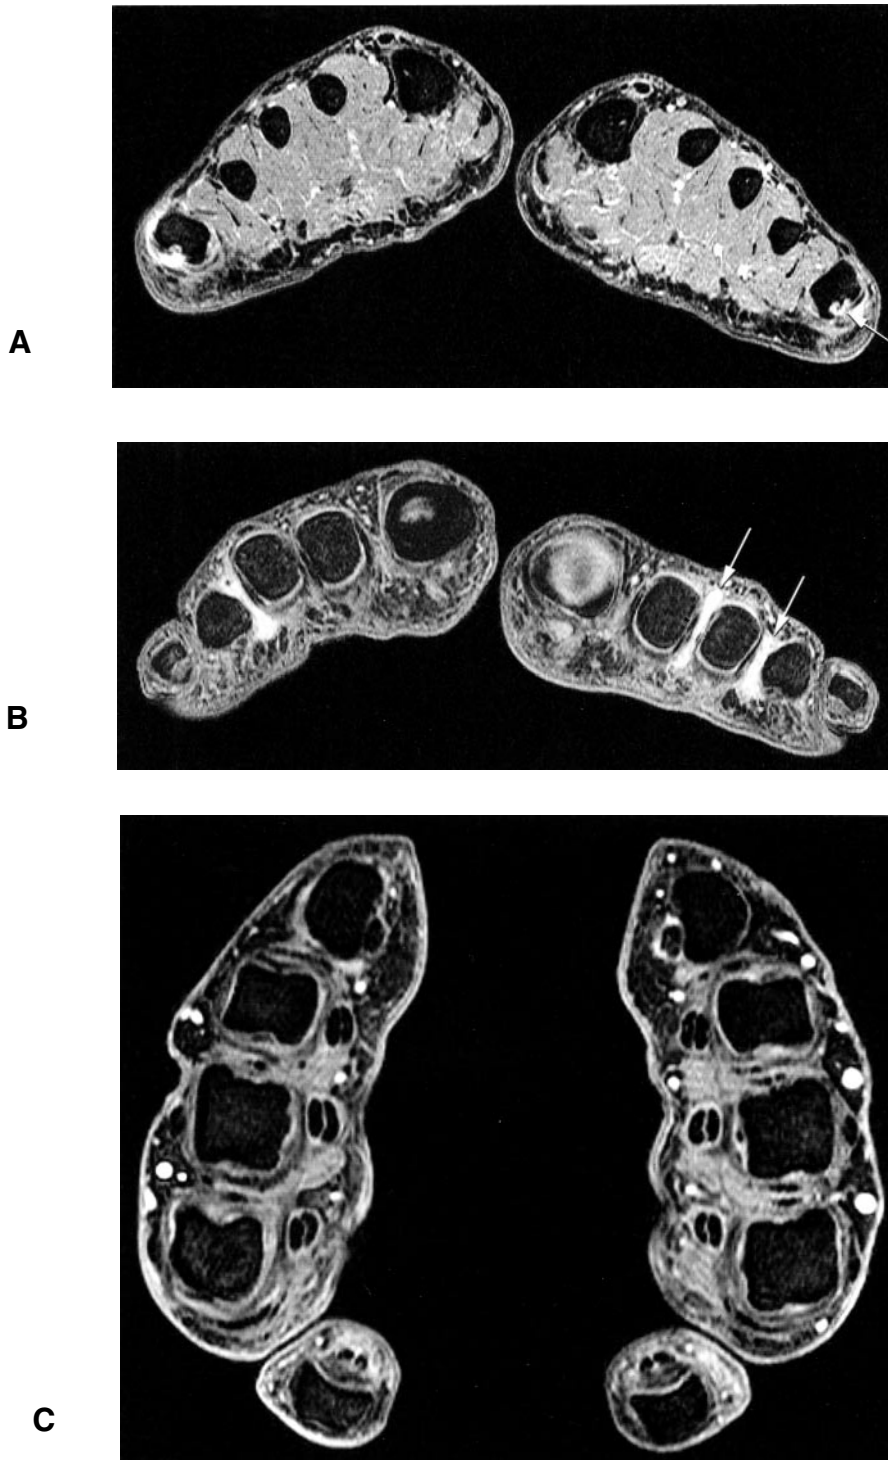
Axial fat suppressed gadolinium enhanced 3D FLASH MR image of MTP joints in a 45-year-old man with early RA reveals bilateral osseous erosions on the lateral aspect of the 5th metatarsal head (arrow) (A), as well as intermetatarsal bursitis (arrows) (B). No abnormality was found in the wrist and MCP joints (C).
